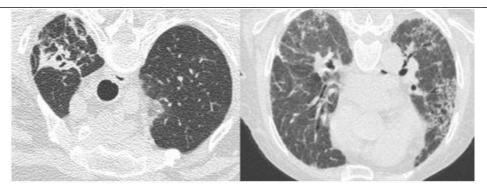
Follow up HRCT of a patient previously positive for COVID 19 antigen shows areas of fibrosis as seen above
